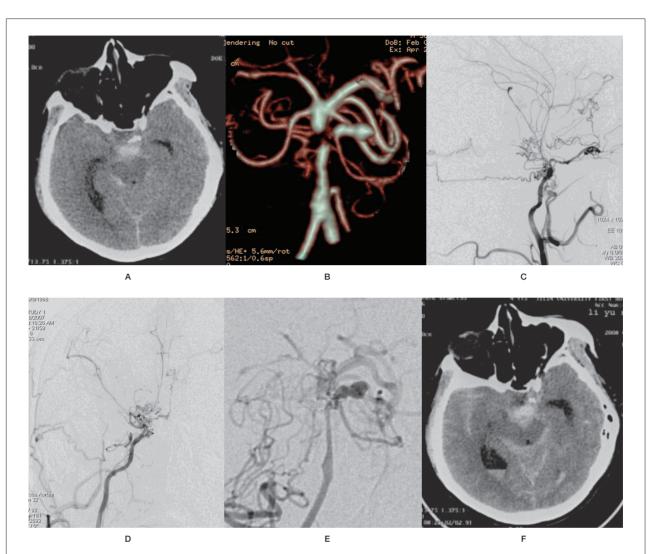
UPB dissecting aneurysm (Case 4). A) CT showing SAH mainly in the interpeduncular cistern. B) CTA showing an aneurysm at the left upper pontine branch of the basilar artery. C,D) DSA revealing the presence of moyamoya disease. E) DSA showing that coil embolization failed to occlude the aneurysm. F) CT showing re-rupture of the aneurysm at the 5-month follow-up.
